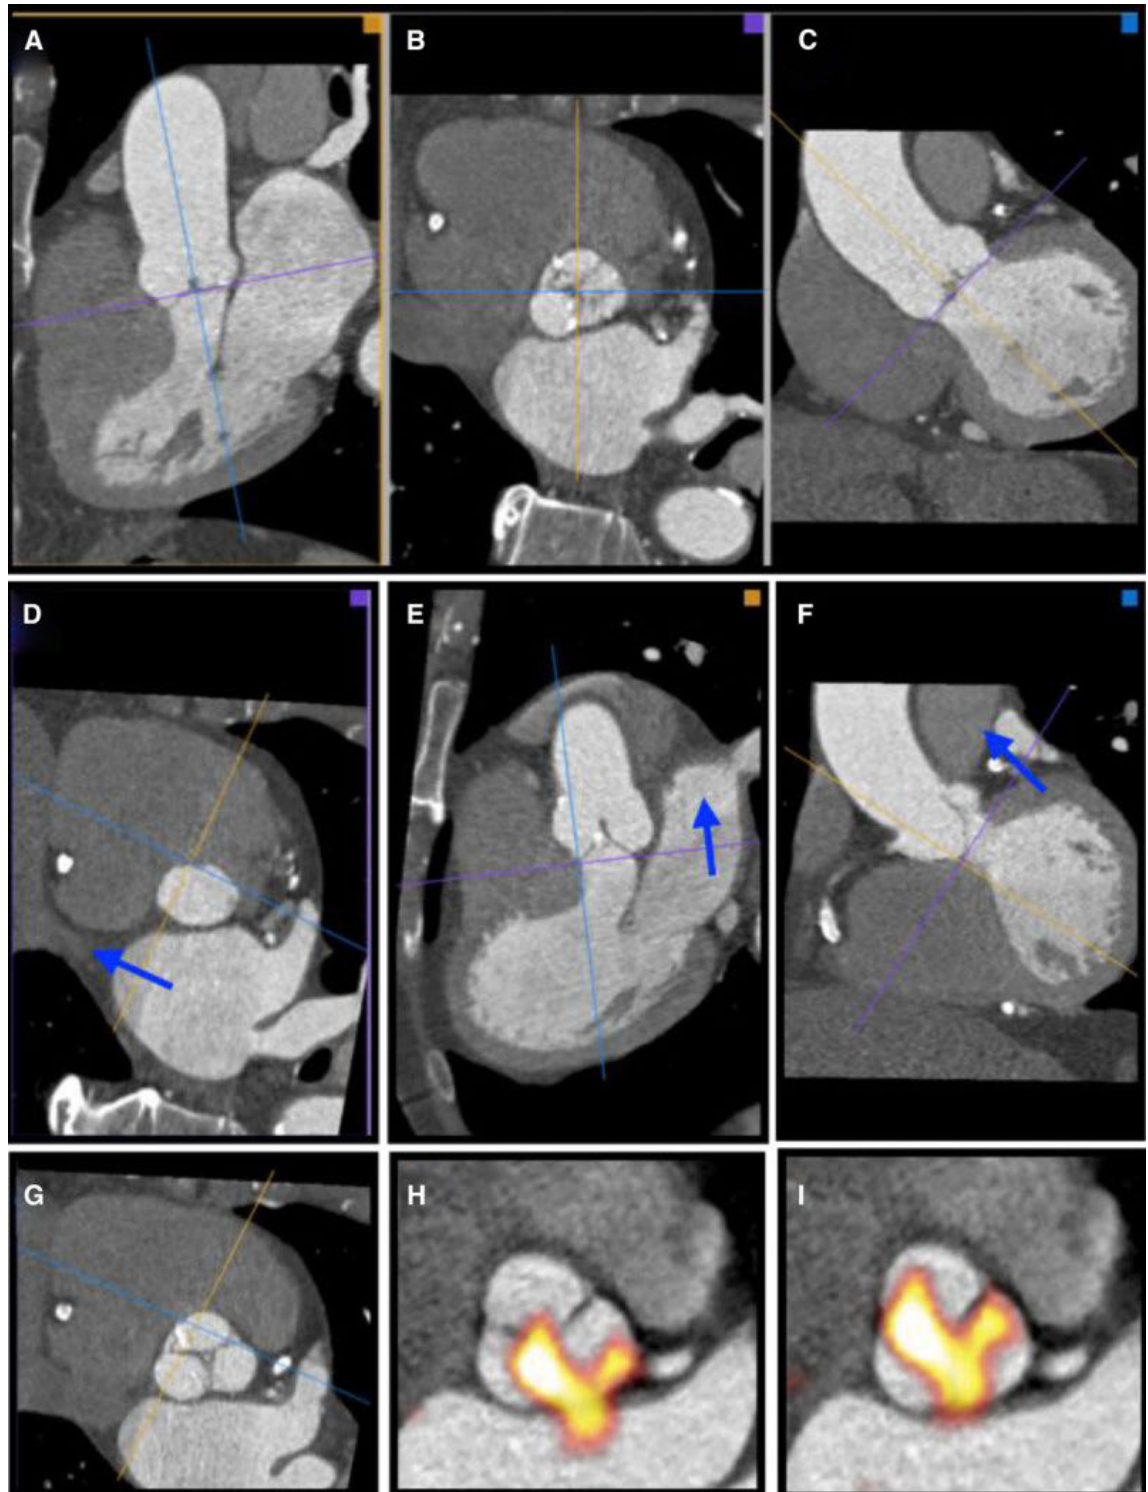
Creation of planar en-face valve images using CT angiography was achieved as follows. First, the CT angiogram is reorientated to get into the approximate plane of the aortic valve by lining up the axial cross hair (purple in this example) using the images in the coronal (a) and sagittal planes (c). This creates an approximate cross sectional image of the aortic valve in the axial frame (b). Scrolling down in the axial frame, the centre of the crosshairs is then placed over the exact point at which the right coronary cusp disappears, identifying the base of that leaflet (d). Similarly, the base of the non-coronary cusp is identified and orthogonal planes adjusted so that the purple plane goes through the base of both these two cusps (d). Finally, the base of the left coronary cusp is found by rotation of the axial cross hairs so that first the cusp comes into view. The image is then slowly rotated in the opposite direction until the point where the leaflet first disappears (the base) is again found (f). This produces an en face image of the valve aligned with the base of all three leaflets (g). Adjacent 3-mm slices are then created in that plane and used for subsequent assessment. These slices are fused with the ^{18}F -Fluoride PET images (h) and careful co-registration performed in 3-dimensions to ensure accurate alignment between the PET and CT images (i).
